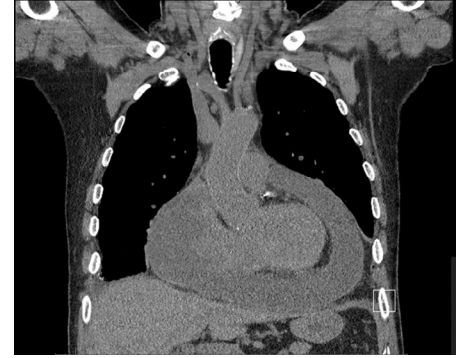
Coronal CT chest showing large pericardial effusion.
